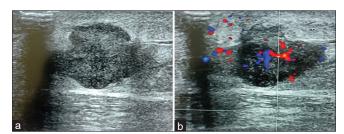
(a) Grayscale ultrasound of a pigmented left leg swelling with (b) color Doppler and a score of 6/9 and USG diagnosis of a malignant lesion. HPE confirmed malignancy (malignant melanoma)
